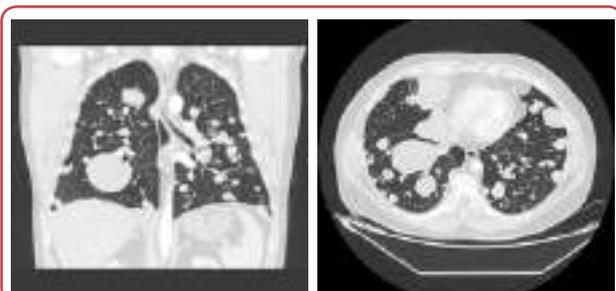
Chest computerised tomography (CT) scan prior to systemic therapy
